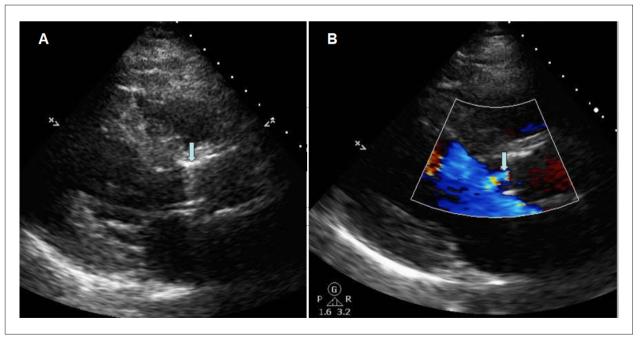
Longitudinal parasternal window of transthoracic echocardiogram showing minimal opening of the aortic valve prosthesis (left arrow) during systole (A) and in color Doppler mode (B), as well as the presence of laminar flow through the prosthesis (right arrow). These findings suggest an increase in the transvalvular gradient and acute prosthesis thrombosis.
